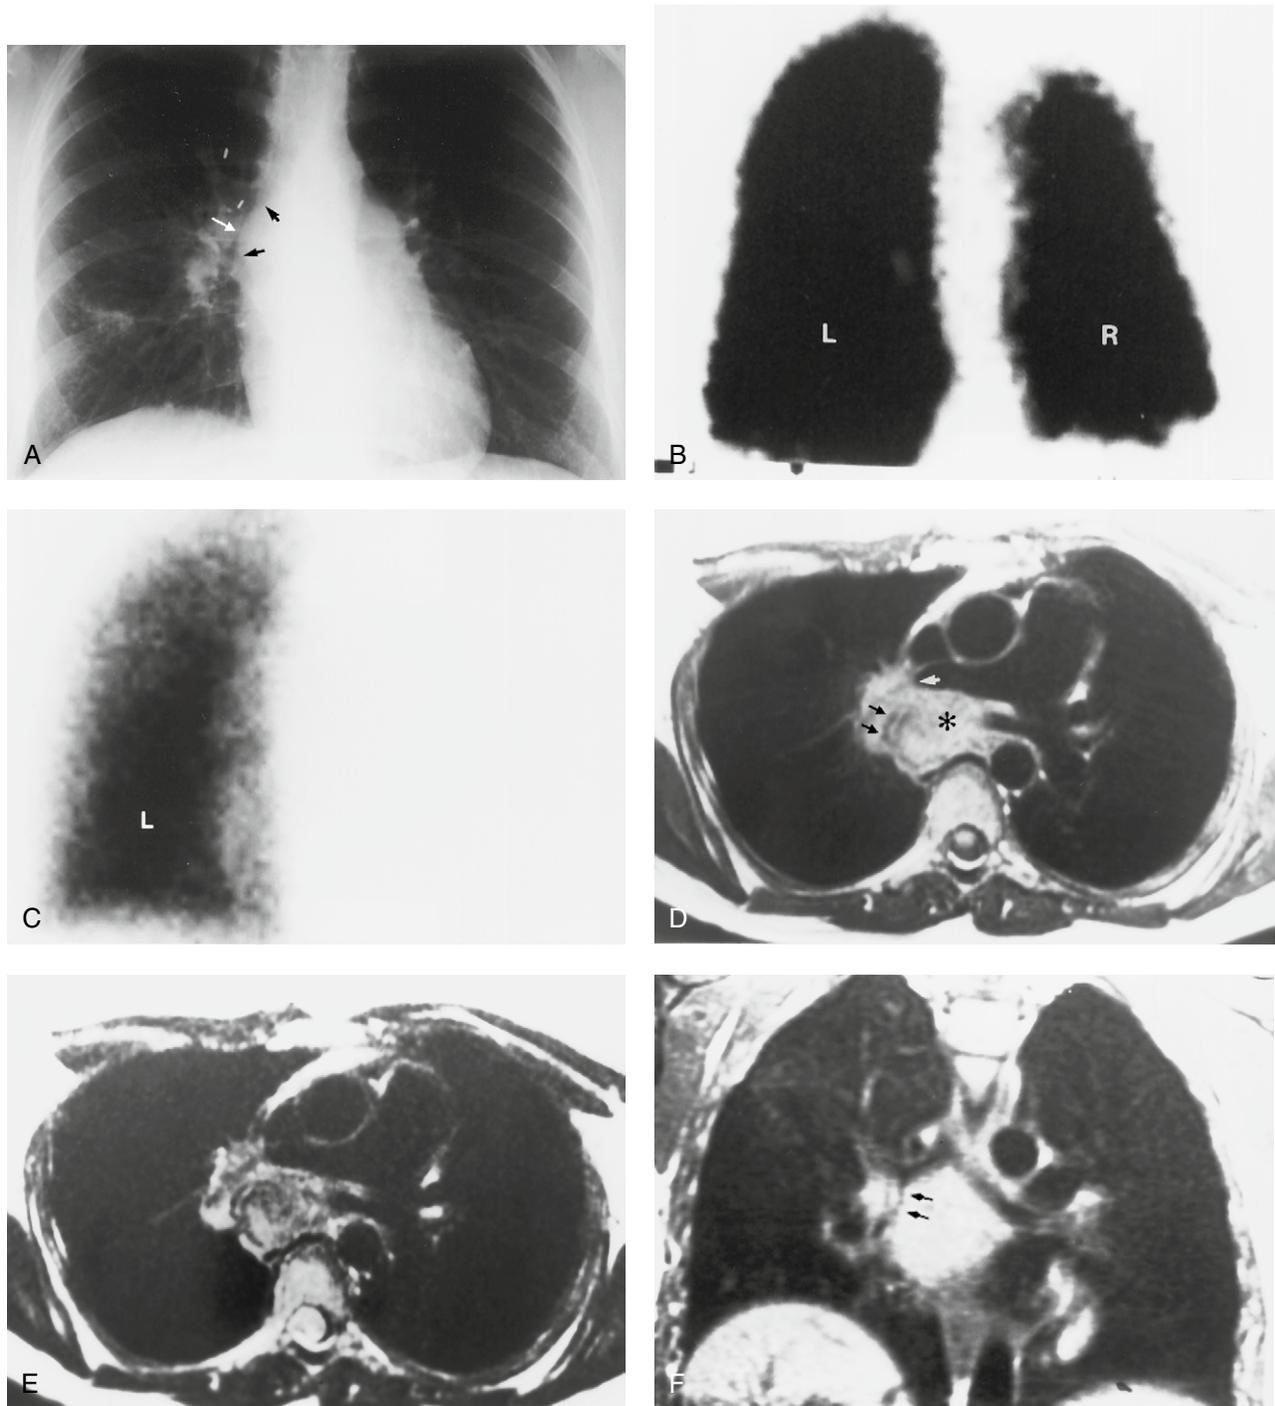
Fibrosing mediastinitis. (A) Coned PA chest radiograph of a 26-year-old woman shows a subtle, large subcarinal mass (*black arrows*) which narrows the transverse diameter of the bronchus intermedius (*white arrow*). The right lung volume is reduced when compared to the left. (B,C) Single posterior images of the right (R) and left (L) lungs from radionuclide ventilation (B) and perfusion (C) lung scans demonstrate reduced lung volume (B) and absent perfusion (C) of the right lung; only the left lung exhibits radionuclide uptake. (D) Axial T1-weighted MR image demonstrates an intermediate signal intensity subcarinal mass (*asterisk*) which obstructs the right interlobar pulmonary artery (*white arrow*) and severely narrows the bronchus intermedius (*black arrows*). (E) Axial T2-weighted MR image through the same level as (D) demonstrates that a large portion of the mass is composed of heterogeneous low signal consistent with fibrous tissue. (F) Coronal T1-weighted MR image demonstrates the large subcarinal mass and the slit-like narrowing of the bronchus intermedius (*arrows*). (Increased signal from within the mass is due to copy artifact.)
